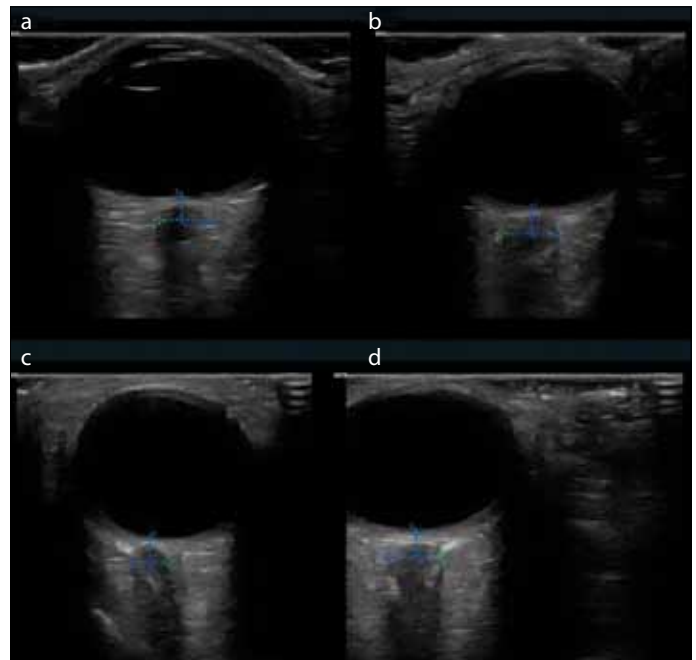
a-d. a, b) Bilaterally increased optic nerve sheath diameters measured sonographically. c, d) Bilaterally decreased optic nerve sheath diameters after the therapy
